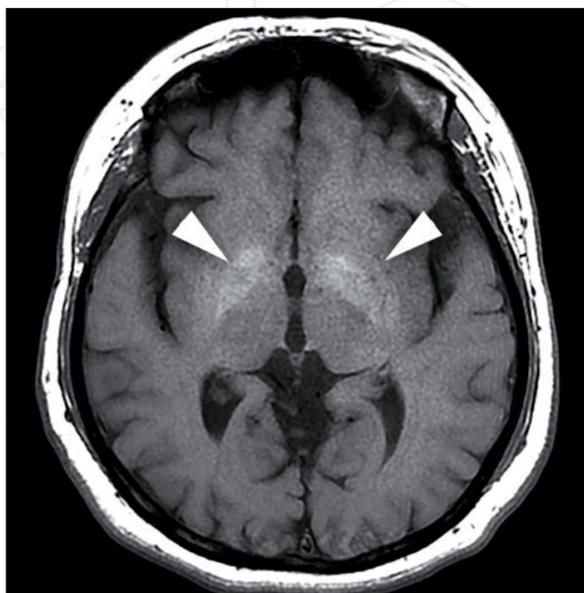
Unenhanced T1-weighted MR image. Signal increase on unenhanced T1-weighted MR image in the basal ganglia, which is indicated by arrowheads.
